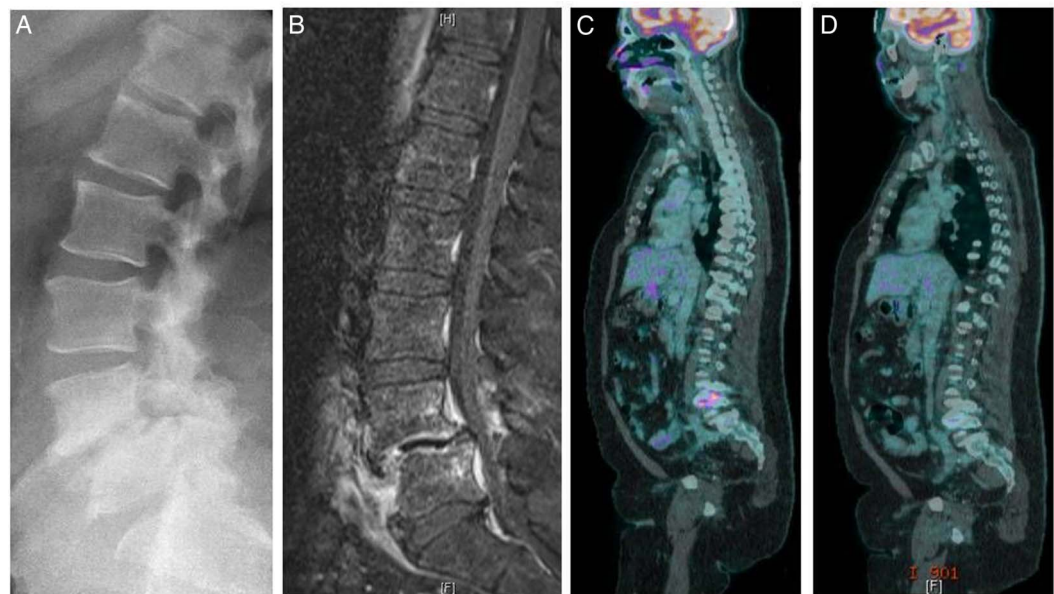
(A) Lateral lumbar radiograph revealing a L4-L5 anterolisthesis; (B) MRI of the lumbar spine, T1-weighted gadolinium sequence, showing a gadolinium enhancement of the L4-L5 vertebral endplates; (C) Positron emission tomography (PET) scan image fusion showing an intense uptake of the L4-L5 space with a maximum standardised uptake value of 7.4; (D) PET scan image fusion showing a significant reduction of the fluorescent deoxyglucose uptake of the L4-L5 space after 10 months of treatment.
